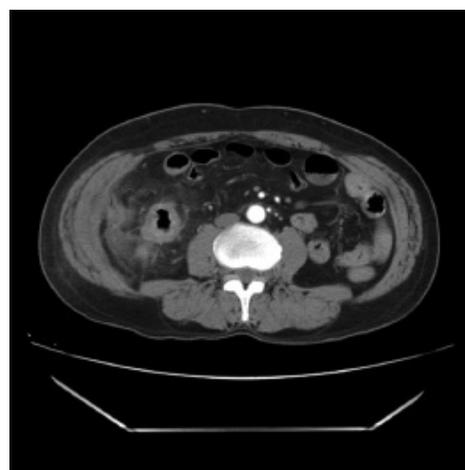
Axial contrast-enhanced computed tomography showing wall thickening of the ascending colon (arrows) with nodular margin and peri colonic fat stranding suggestive of malignancy - T3 tumor staging
